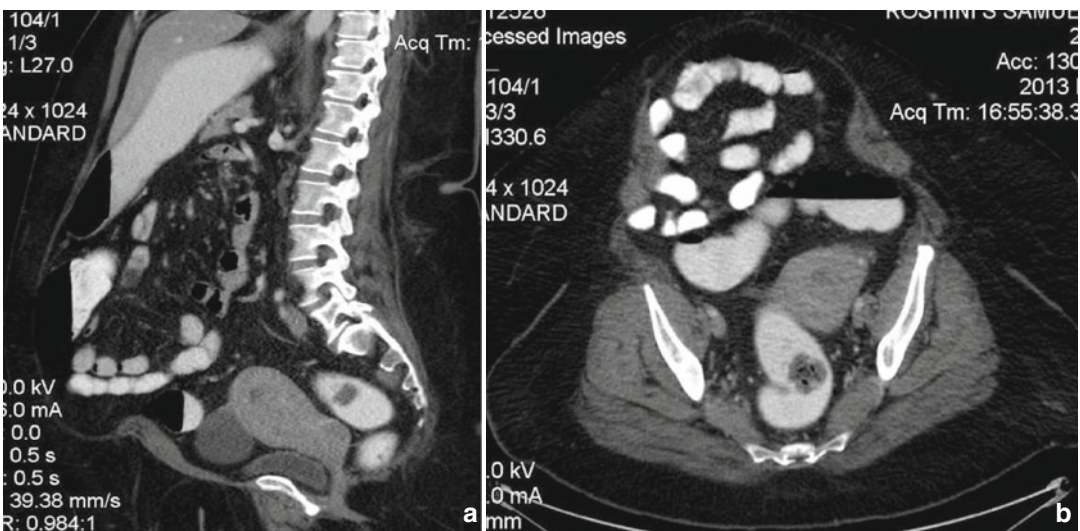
(a, b) Contrast-enhanced sagittal and axial CT images showing central heterogeneous mass (proven FIGO stage 2 endometrioid adenocarcinoma). It is difficult to delineate cervical infiltration on CT scan
